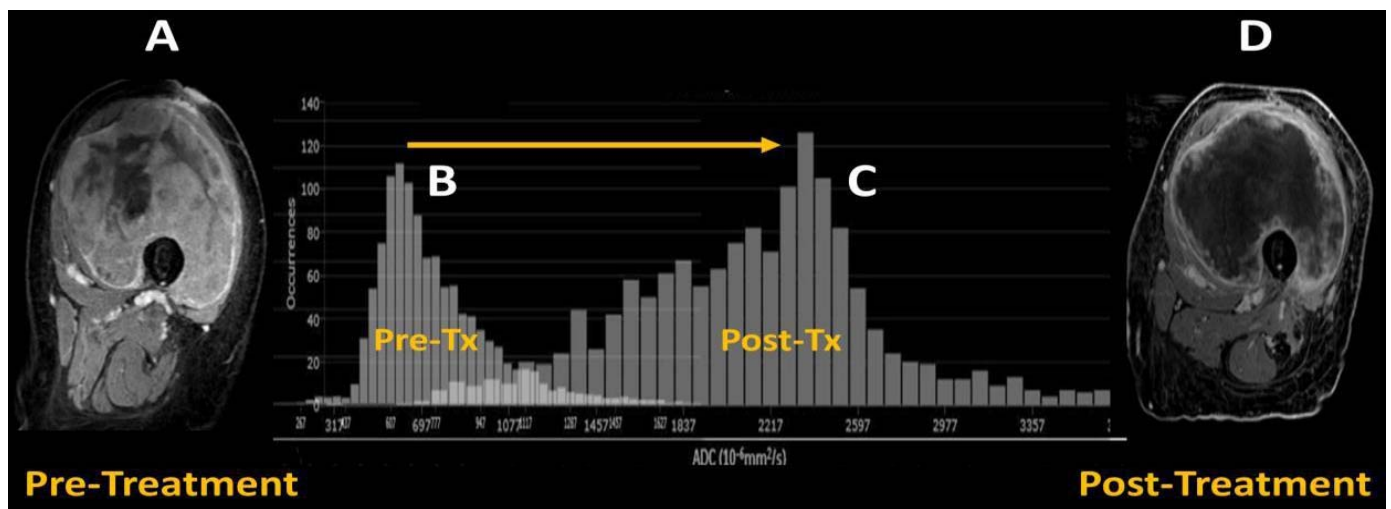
Pre-therapeutic contrast-enhanced MRI of UPS of the left thigh (A) with predominant solid internal enhancement and corresponding left-sided ADC histogram (B) with positive skewness. Post-therapeutic contrast-enhanced MRI of the same lesion (D) demonstrating highly diminished solid enhancement and corresponding right-sided ADC histogram (C) with negative skewness. The figure was modified with permission from the authors, Valenzuela, R.F. et al. [2].
